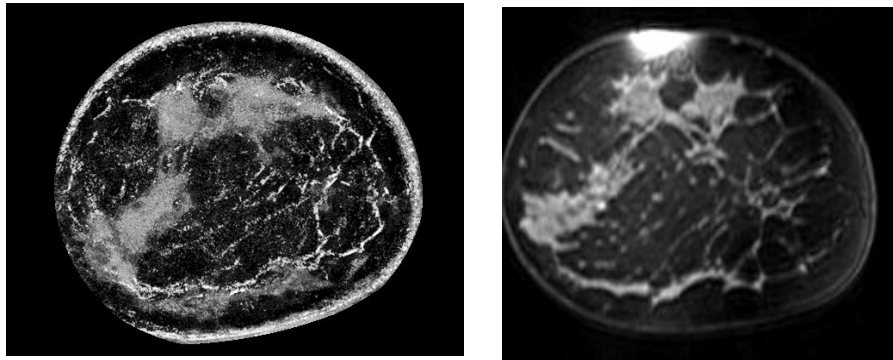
(Left) UST fusion image using reflection, sound speed and attenuation data shows comparable anatomic distribution of fat, fibroglandular tissue and fibrous bands as the MRI image (Right) from a corresponding coronal level through the breast.
